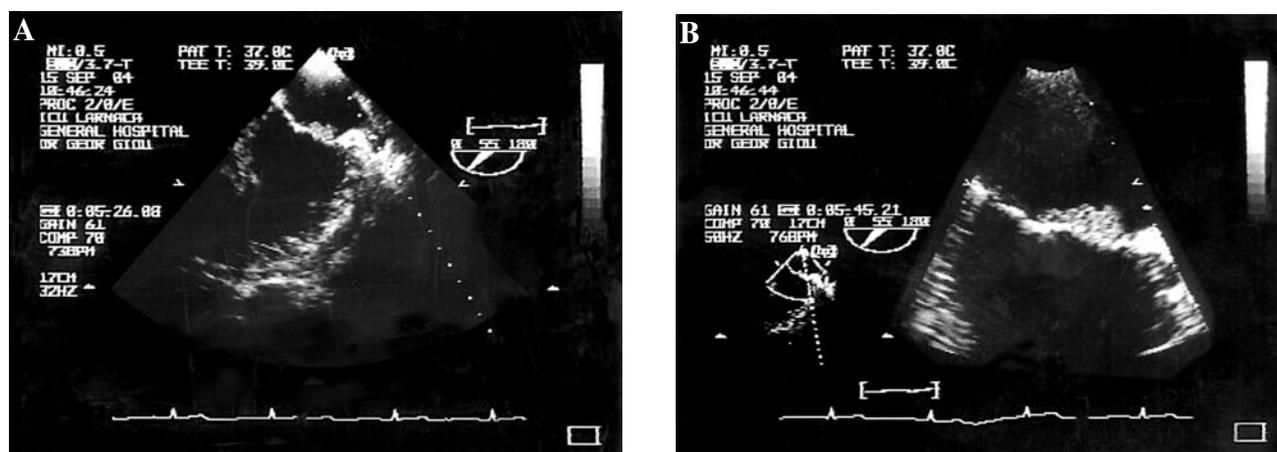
A: Transesophageal echocardiogram (mid-esophageal two-chamber view, 55°) revealing non-pedunculated apposing vegetations on the atrial surface of the anterior mitral valve leaflet. B: Shows a magnification.
